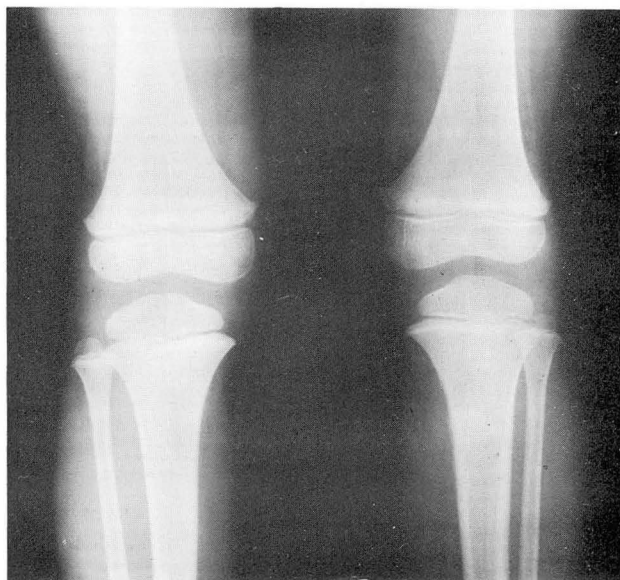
Case 1. Roentgenogram taken on May 31, 1962, showing stress fracture of the left tibia.
